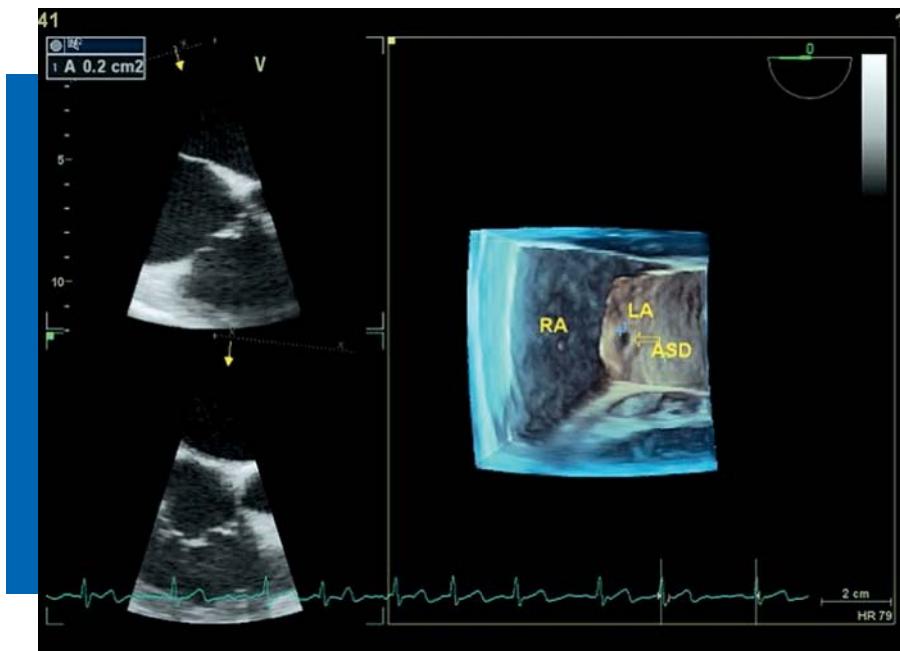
Three-dimensional transesophageal echocardiography showing atrial septal defect; view from the left atrium.
